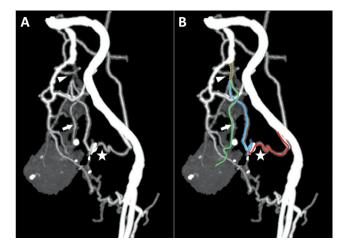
(A). MIP CTA image shows severe atherosclerosis and total occlusion of the anterior division of the left internal iliac artery (arrow head). The distal portion of the anterior division is supplied by a collateral blood from the left inferior epigastric artery (star) to the obturator artery. The left prostatic artery originates from this segment (arrow). (B) MIP CTA image with explantation. Anterior division of the left internal artery (yellow dots line); collateral from left inferior epigastric artery (red line); left obturator artery (blue line); left prostatic artery (green line).
